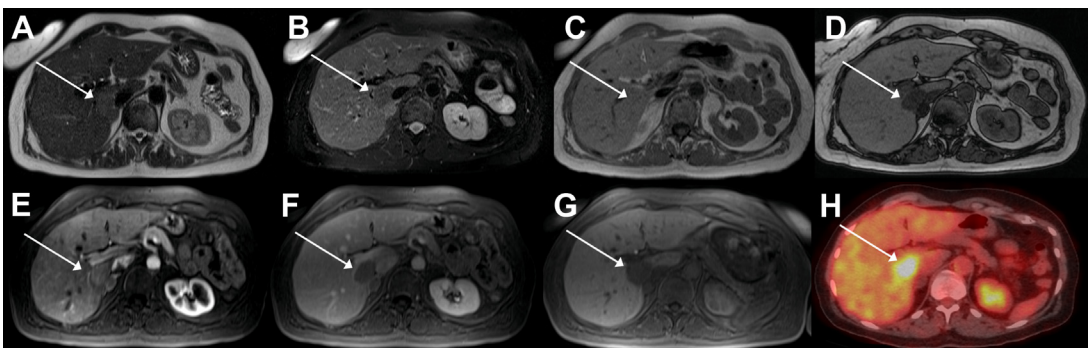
HNF1 α -inactivated HCA with hypermetabolism on 18F-FDG PET/CT. Typical HNF1 α -inactivated HCA, slightly hyperintense on T2 HASTE (A) but hypointense on T2-weighted fat-saturated image (B), related to the diffuse and homogeneous fat content on the lesion as demonstrated by signal dropout in the T1-opposed-phase-weighted image (C, D). On postcontrast sequences after injection of gadobenate dimeglumine (0.1 mL/kg), the lesion demonstrated faint arterial hyperenhancement (E), with hypointensity in the delayed phase (F) and in the hepatobiliary phase (G). This lesion demonstrated marked hypermetabolism on 18F-FDG PET/CT (H).
